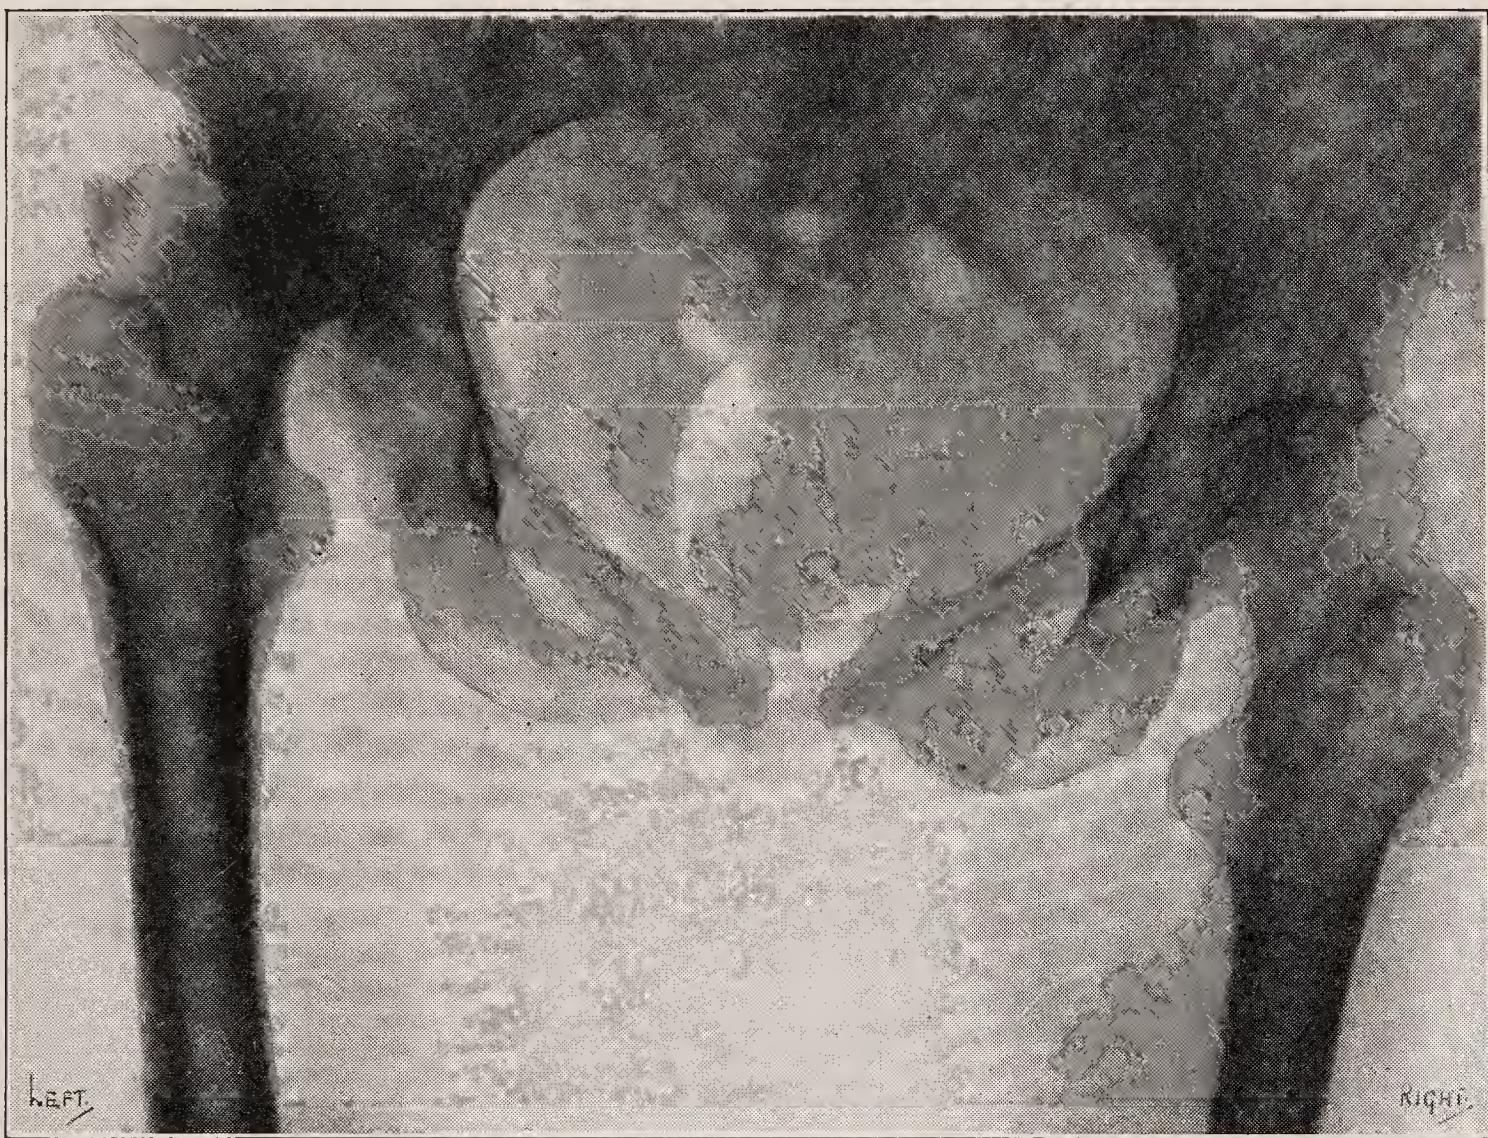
X-ray of tuberculosis of the hip in an adult (Thurstan-Holland).
